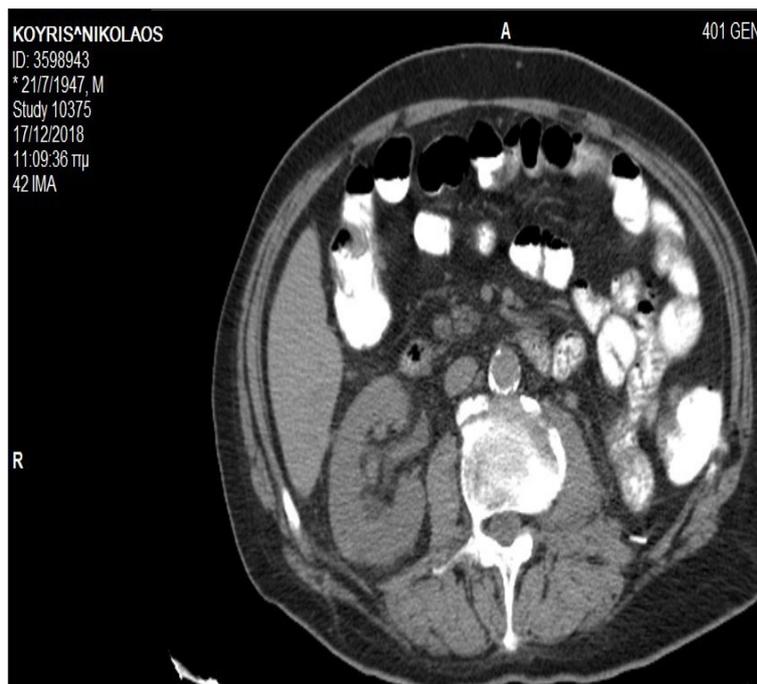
An abdomen CT scan after 10 months of treatment with TKIs showing normal appearance of the transverse colon.
